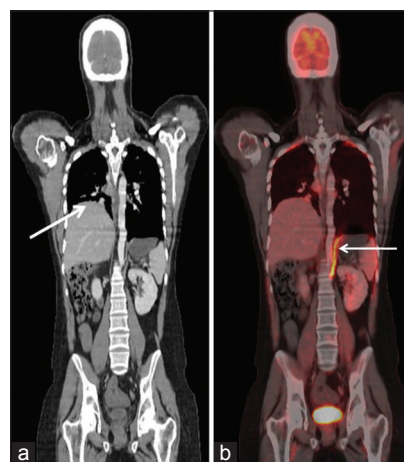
Coronal computed tomography (CT) image revealed elevated right hemi-diaphragm [arrow in Figure 2a], suggestive of right diaphragmatic paralysis. Fused positron emission tomography/CT image [coronal slice, arrow in Figure 2b], shows intense fluorodeoxyglucose uptake in left hemi-diaphragm. The maximum standardized uptake value of this uptake was 6.1 (normalized for body surface area)
